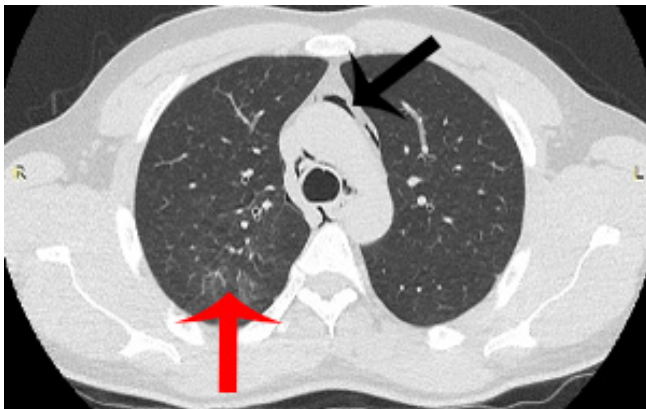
Chest CT showing a focal ground glass opacity (red arrow) and air in the mediastinum (black arrow).
